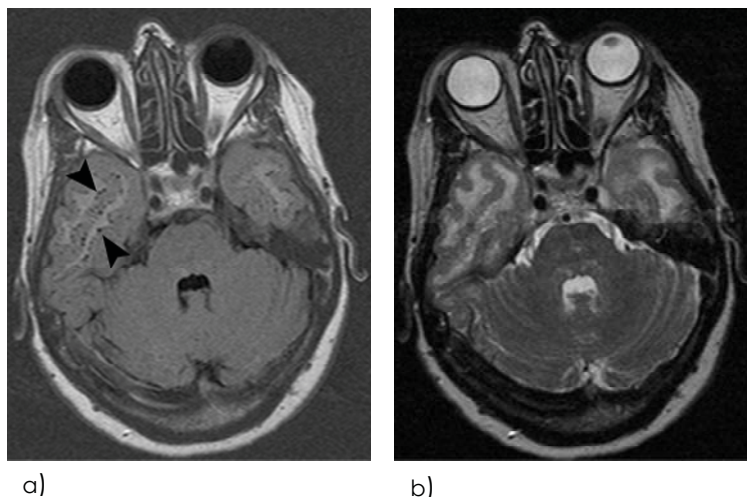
Axial MR images in patient with CADASIL at the level of the pons. Hyperintense confluent white matter lesions in the temporal lobe are visible on (a) a FLAIR image and a (b) T2-weighted image. On the FLAIR image, the SLLs (arrowheads) are clearly visible on the T2-weighted image they hardly be discriminated from the adjacent WMHs.
